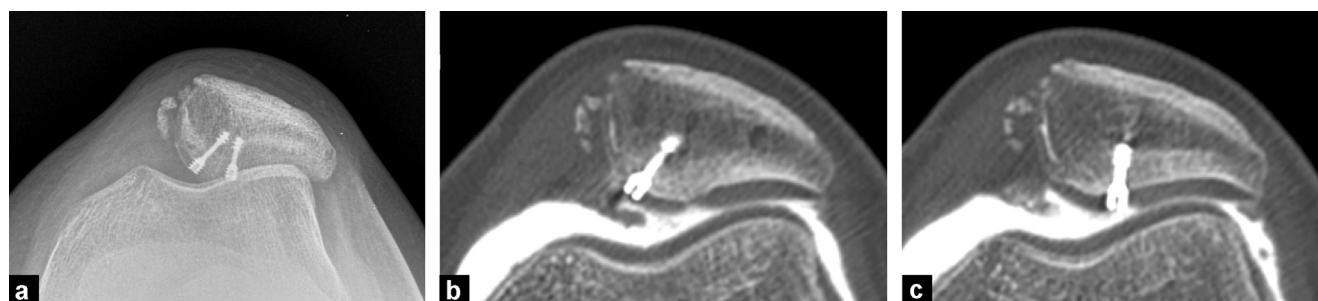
Osteointegration and recovery of articular congruity after osteosynthesis of an osteochondral fragment with 2 metallic screws following lateral patellar dislocation. X-rays, transverse view (a), and CT arthrography, axial images (b and c).
